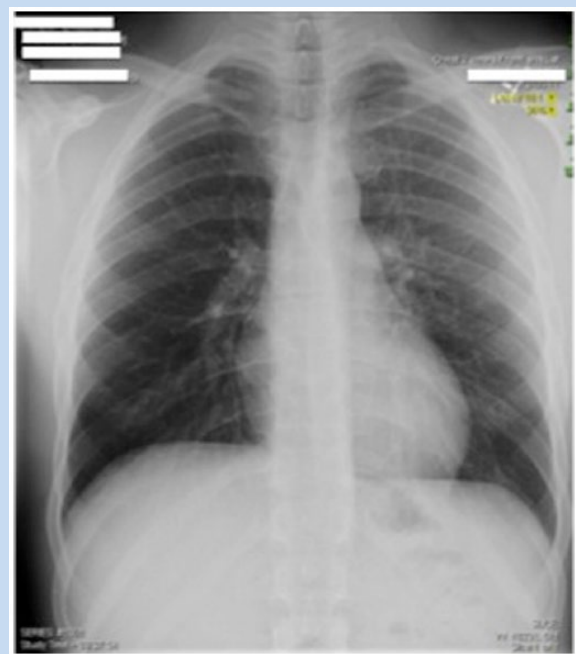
Anteroposterior chest radiograph taken on the day of injury. This radiograph was read as normal, with no evidence of fracture or dislocation.
